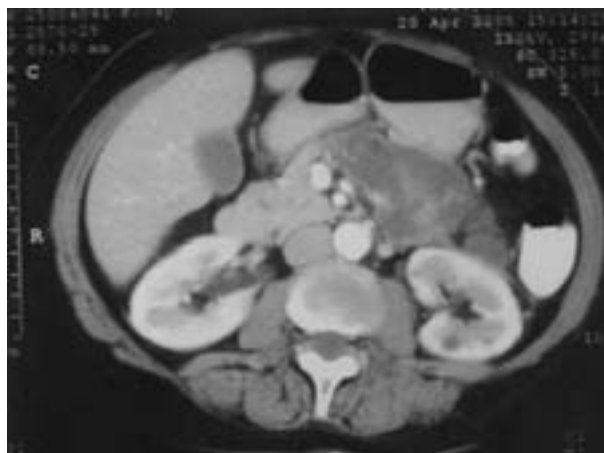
CT SCAN 05.04.20 - Peripheral delimitation of fluid collection by radiographic contrast.
